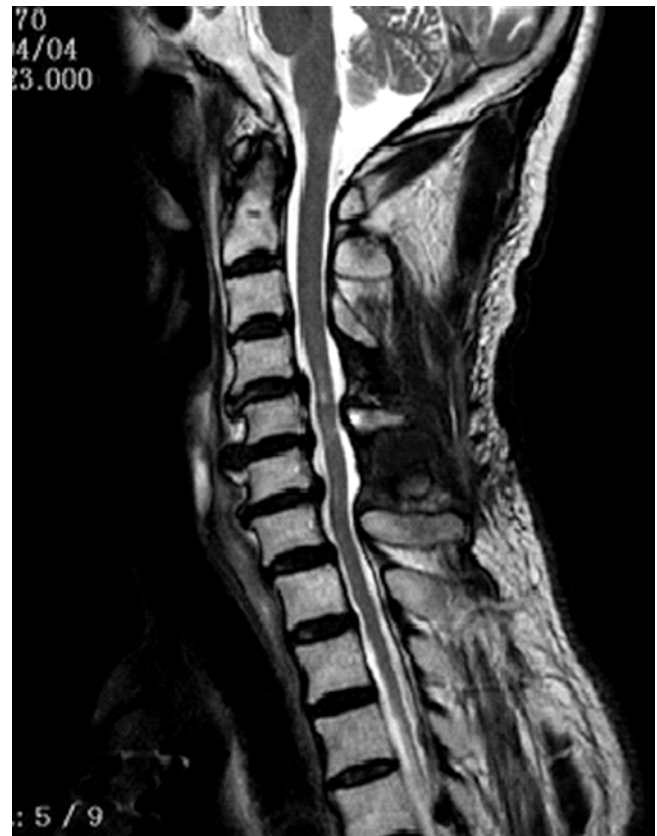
Postoperative cervical MRI taken 4 months after surgery demonstrated adequate decompression of the spinal cord associated with subarachnoid space expansion
